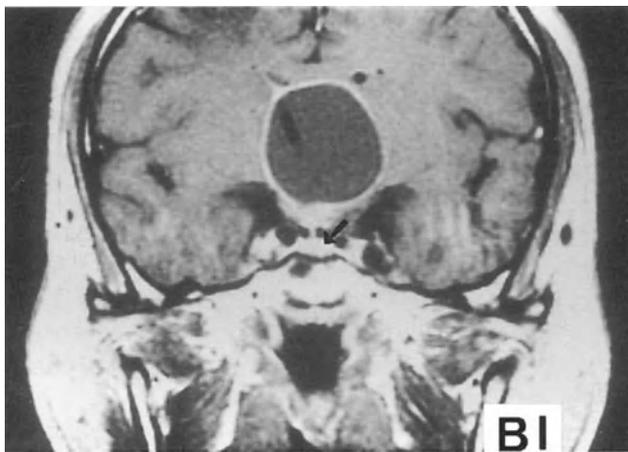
Craniopharyngioma imaging: (A) Plain skull radiography showing suprasellar calcification. (B) MRI (T1 weighted coronal view enhanced by gadolinium). (B1) predominantly cystic suprasellar lesion. A normal pituitary gland is observed (arrow). (B2) mixed (solid / cystic) sellar and suprasellar tumor.
